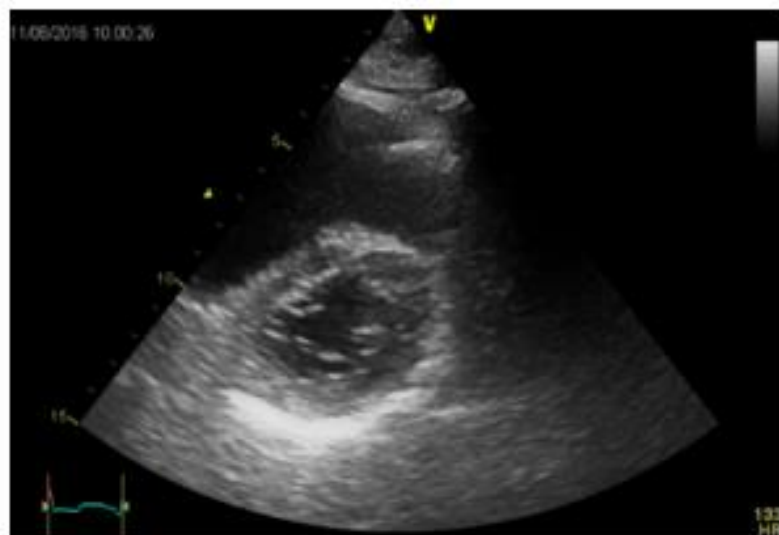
Transthoracic cardiac ultrasound - pericardial fluid slide
